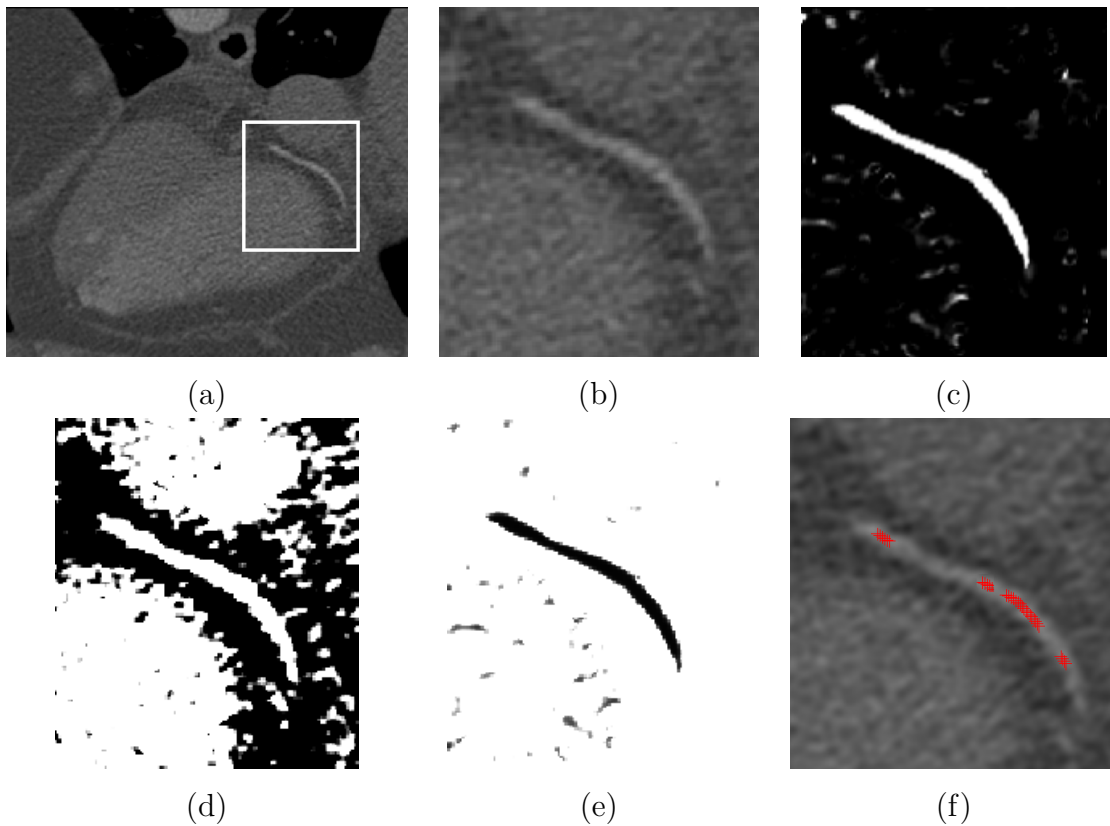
(a): A slice of a CTA image containing the distal part of the right coronary artery; (b): Region of interest from the highlighted area in (a); (c): Vesselness image of (b); (d): Weighting image of (b) computed by Equation 5.1; (e): Cost image of (b) computed by Equation 5.2; (f): Extracted centreline marked by red crosses. Note only part of the extracted centreline is visible in this 2D slice.
